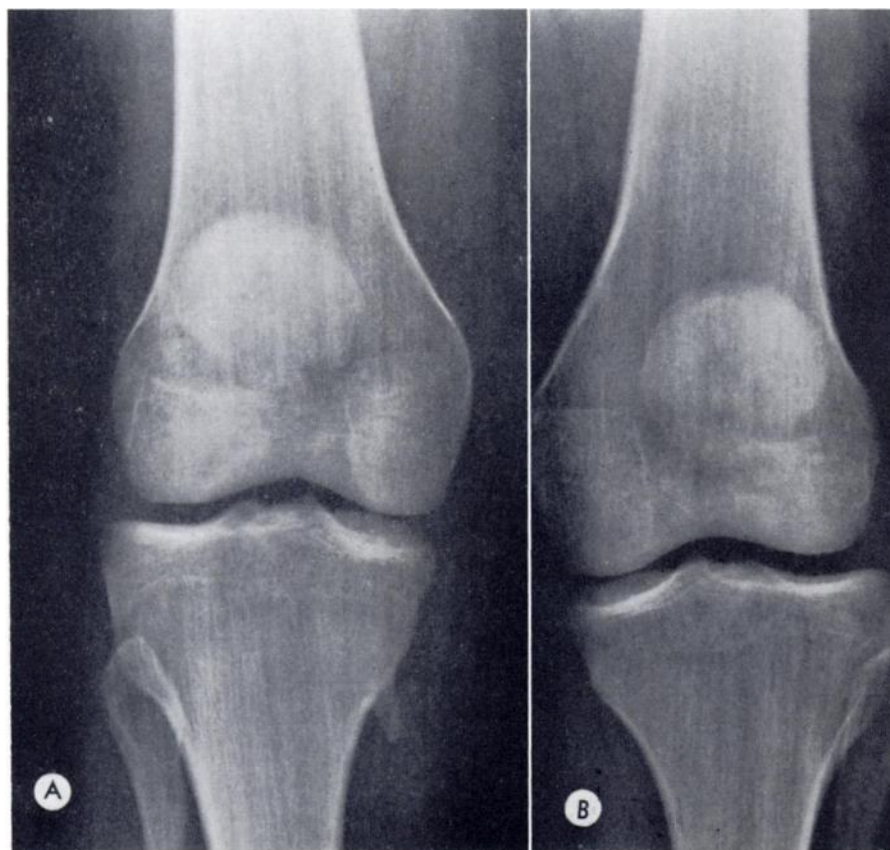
Case 1. (A and B) Frontal roentgenograms of the knees at the age of 19 years. Linear striations in the distal femora and proximal tibiae parallel to the axis of the bone shafts. These changes are more prominent in the femora. Note tibial osteochondroma on the right (A).
